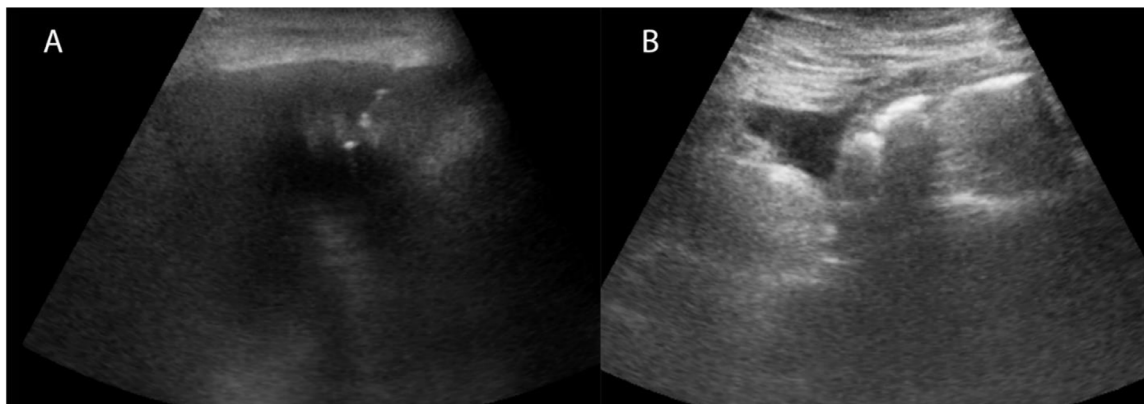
(A) Ultrasound-guided paracentesis was performed with return of chylous ascites. (B) After draining 39.5 liters of ascites the catheter was clamped and there was only trace ascites remaining.
